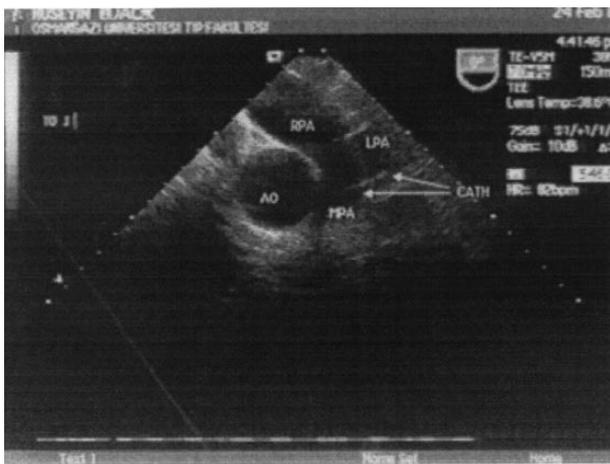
Transesophageal echocardiographic view of the cardioversion catheter placed in left pulmonary artery¹⁰. AO = aorta; cath = catheter; IVC=inferior vena cava; LA = left atrium; LPA = left pulmonary artery; MPA = main pulmonary artery; RA = right atrium; RPA = right pulmonary artery; SVC = superior vena cava.
